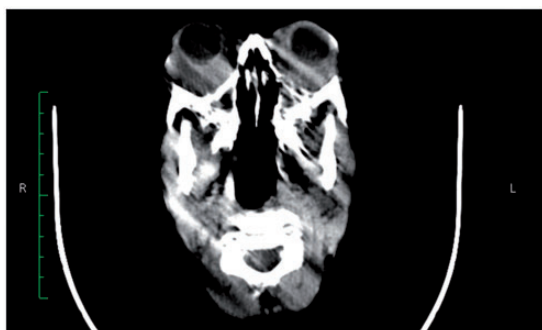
Orbital CT scan, axial view, showing a bilateral, symmetrical proptosis and a bilateral symmetrical hypertrophy of extraocular muscles and tendons.
